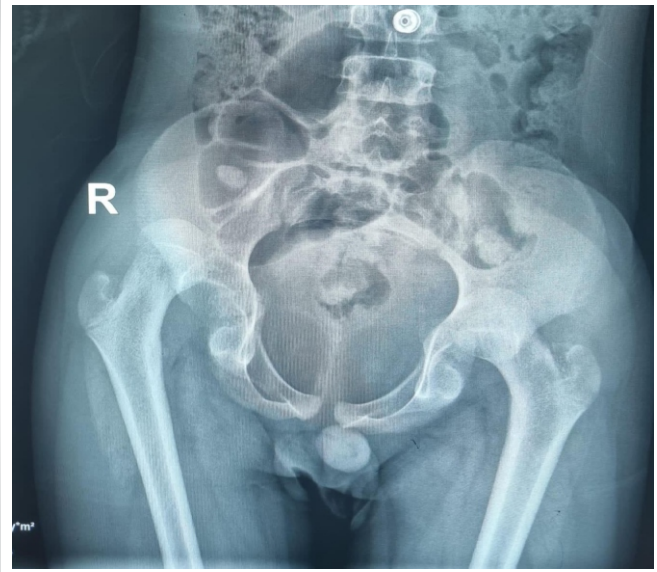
X-ray at presentation.
